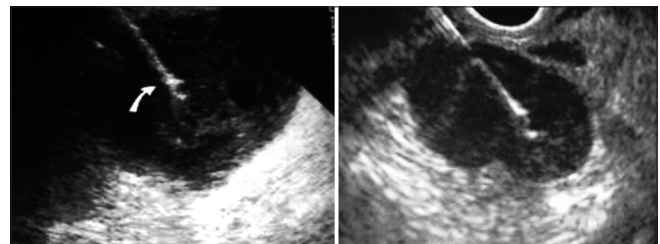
Ultrasound images showing breast abscesses with internal echoes and septations. Percutaneous aspiration needle is seen in the cavity of breast abscesses
